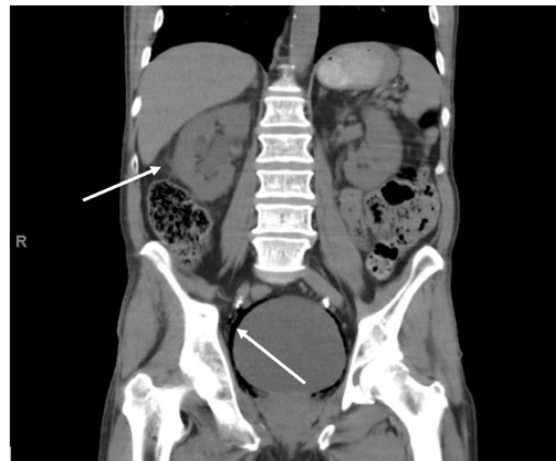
The coronal imaging from the initial CT scan of the abdomen and pelvis revealing emphysematous changes within the bladder wall and perinephric fat stranding.
